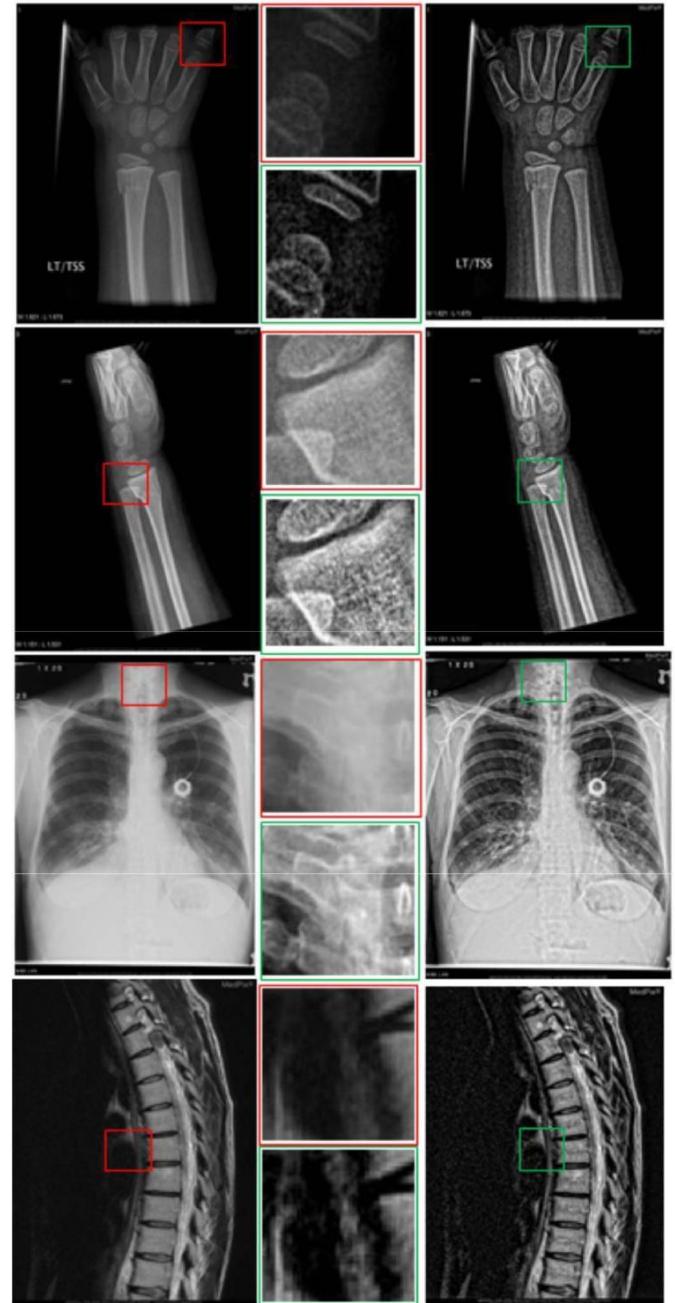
Visual evaluation of our contrast enhancement algorithm. (Left) Input radiography images. (Center) Corresponding highlights enlarged. (Right) Detail enhanced output images generated.
